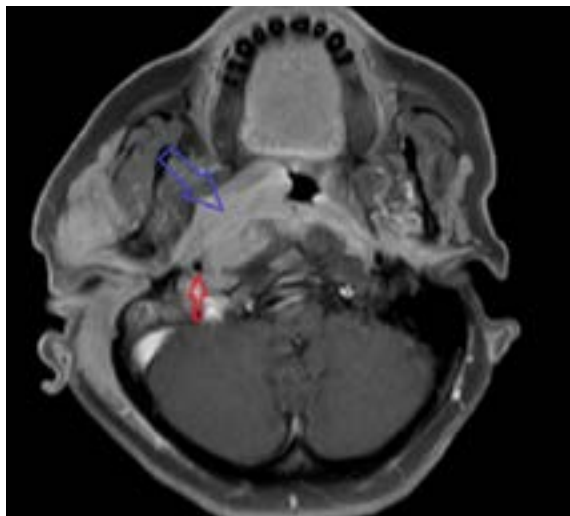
Contrast-enhanced neck magnetic resonance imaging axial section revealed a mass lesion starting from the right half of the nasopharynx (indicated by blue arrow) and surrounding the internal carotid artery (indicated by red arrow) by 360 degrees.
